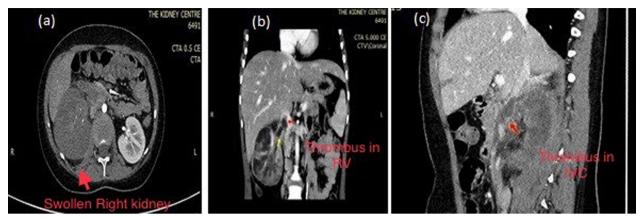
a Computed tomography angiography in the arterial phase showing an enlarged, swollen right kidney with loss of corticomedullary differentiation. b Computed tomography angiography showing an organized echodense thrombus in the venous phase, obstructing the right renal vein and extending to the inferior vena cava. c Ccomputed tomography angiography in the sagittal view of the venous phase image showing the extension of the thrombus from the right renal vein into the inferior vena cava to the infrahepatic level
